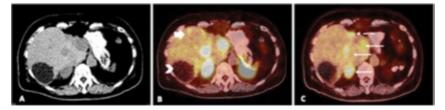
Dual tracer (Gallium-DOTATATE [GaTate] & 1*F-FDG) PET-CT scan protocol. 62-yearold lady was referred for peptide receptor radionuclide therapy. She had Grade 2 pancreatic neuroendocrine tumour. Distal pancreatectomy and radiofrequency ablation to liver were performed. She developed progression during octreotide therapy. Fused GaTate images (B) and FDG images (C) showed previous RFA (arrow head), discordant GaTate lesion (broad arrow), concordant GaTate and FDG lesions (thin arrow) and discordant FDG lesion (dotted arrow). These features demonstrate presence of both intra-tumoural and inter-tumoural heterogeneity.
